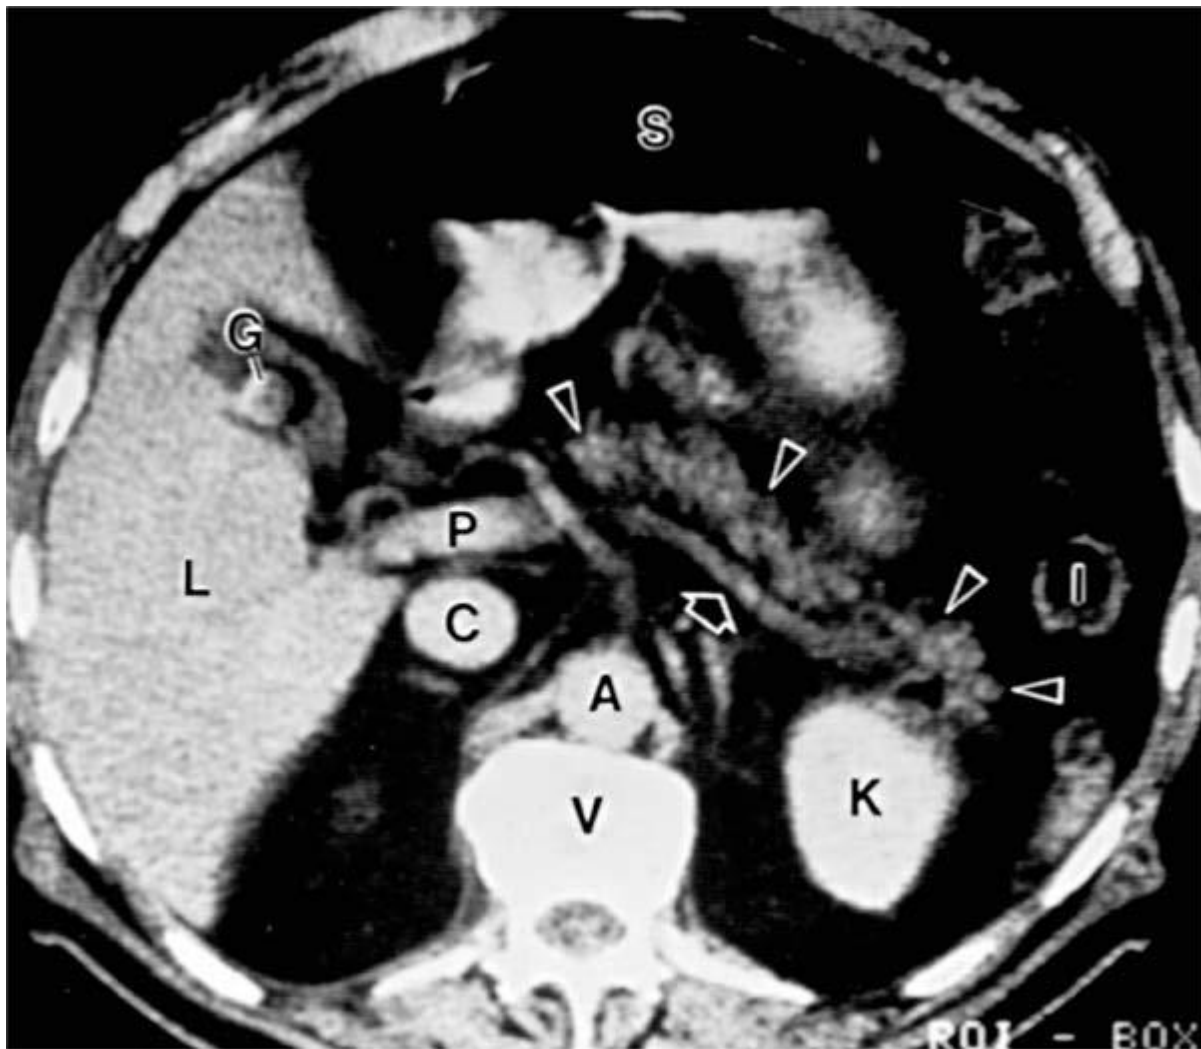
Normal anatomic relation of the pancreas with other intraabdominal structures as shown by computed tomography. The borders of the pancreas are indicated by arrowheads. The splenic vein is indicated by an arrow. A, aorta; C, vena cava; G, incidental gallstone; I, small intestine; K, left kidney; L, liver; P, portal vein; S, stomach; V, vertebra.
